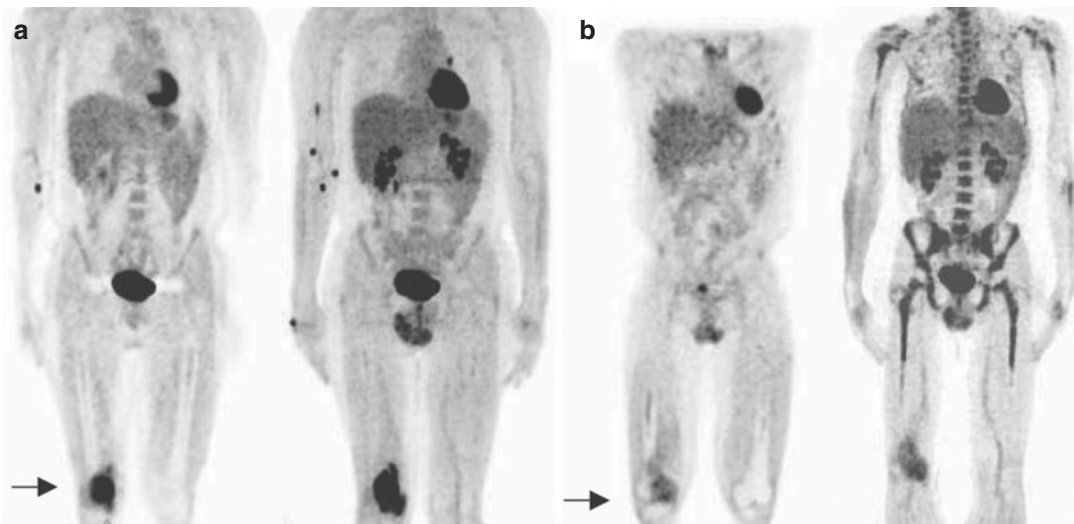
(a, b) ^{18}F -FDG-PET study of a patient with osteogenic sarcoma of the distal right femur showing increased uptake and SUV value of 9.6. (b) Follow-up
